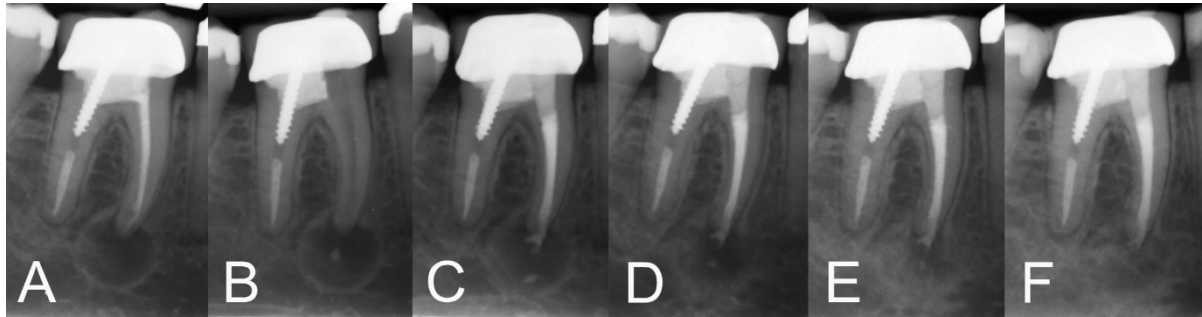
Clinical radiographs of the case. (A) Pre-operative periapical radiograph showing a well-defined radiolucent lesion with a corticated border at the apex of the mesial root of tooth #46, indicative of a cystic apical lesion associated with root resorption. (B) Access to the mesial canals of tooth #46 was achieved, and thorough cleaning and shaping were performed using hand and rotary instruments. (C) The canals were filled and sealed with CEM cement as the obturation biomaterial. (D) Periapical radiograph taken at 6-month recall showing a mild reduction in the size of the periapical lesion. (E) Periapical radiograph taken at 12-month follow-up showing more reduction in the size of the cystic lesion. (F) Periapical radiograph taken at the 54-month follow-up, demonstrating complete healing of the cystic apical lesion, with no signs of recurrence.
